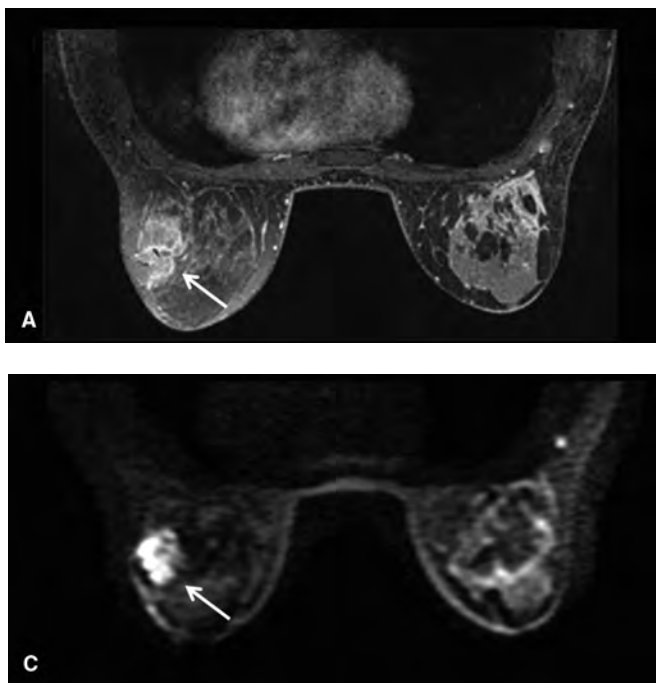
Diffusion-weighted imaging: 36-year-old premenopausal woman. (A) T1-weighted postcontrast axial image shows heterogeneously dense breast with a 3.7-cm rim enhancing lobulated mass that was a biopsy-proven carcinoma. (B) ADC map demonstrates the primary tumor to have lower diffusion capacity ($1.27 \times 10^3 \text{ mm}^2/\text{s}$) than the surrounding fibroglandular tissue ($2.41 \times 10^3 \text{ mm}^2/\text{s}$). (C) DWI image showing the left breast cancer brighter than the surrounding breast tissue (arrow). (Courtesy of Dr. Sunitha Thakur.)
